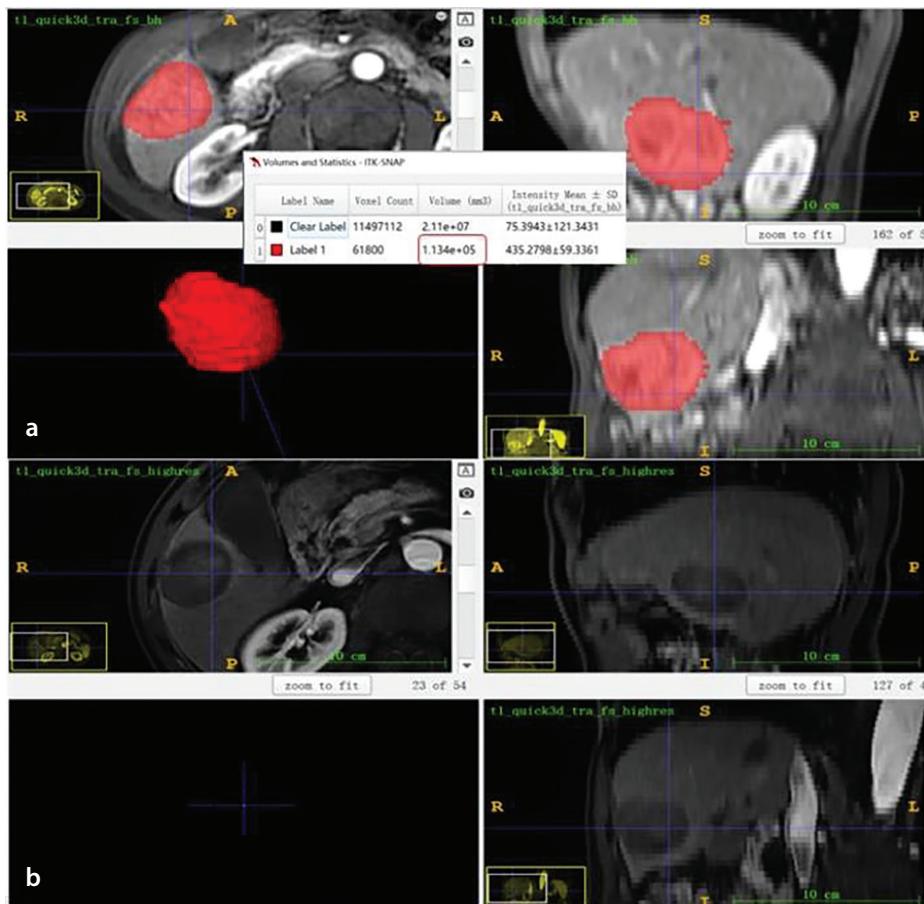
Images of a 62-year-old male patient with hepatocellular carcinoma. An arterial phase contrast-enhanced T1-weighted image revealed a tumor with a volume of $113,400 \text{ mm}^3$ in the right liver lobe before treatment (a). No enhancement was observed in the tumor (complete necrosis) 30 days after transarterial chemoembolization + microwave ablation (b).
